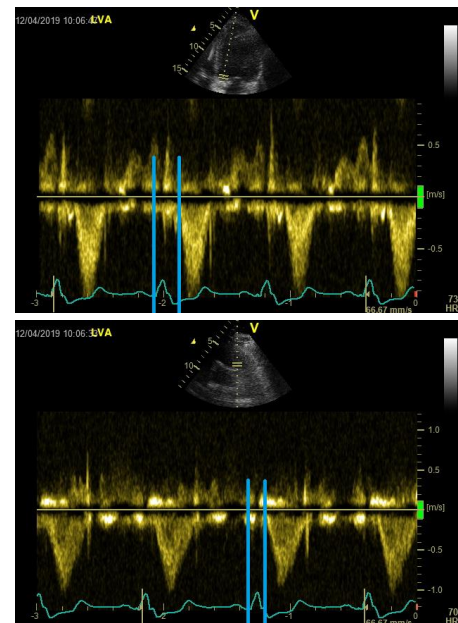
Examples of echocardiography interventricular dyssynchrony measurements. Aortic valve flow at the top, pulmonary valve flow at the bottom (Vivid E9, GE Healthcare).
